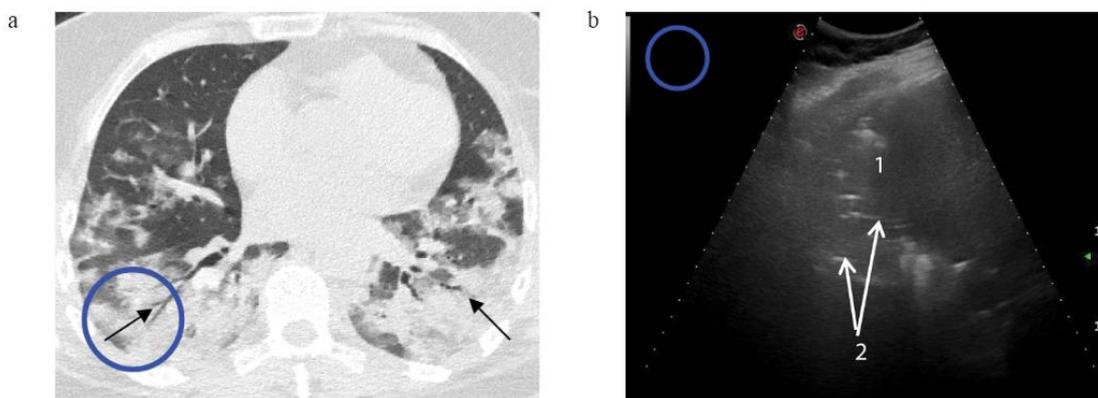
Computed tomography and echogram of the lungs of a 57-year-old woman with COVID-19
